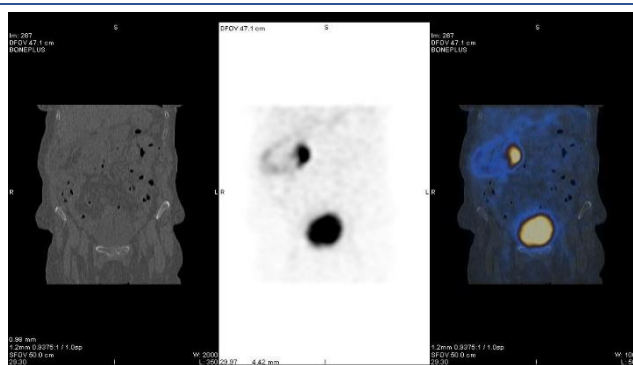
From left to right, the coronal plane shows [^{99m}Tc]Tc-EC accumulation around the right kidney on CT scan, SPECT, and SPECT-CT, respectively
